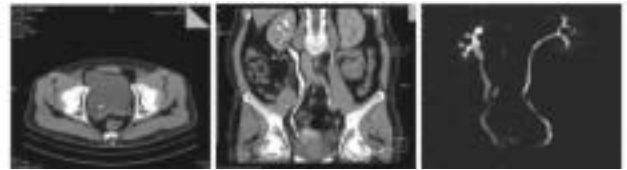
A, B & C : Noncontrast axial CT (A) showing a radiodensity at the right ureterovesical junction (UV junction) s/o calculus. Curved MPR image after contrast opacification (B) depicting the calculus at the right UV junction with proximal hydronephrosis and hydroureter. CT urography using MIP (C) image showing the dilated hydroureter and hydronephrosis proximal to the calculus. The normal non dilated pelvicalyceal system and ureter is seen on the left side.
